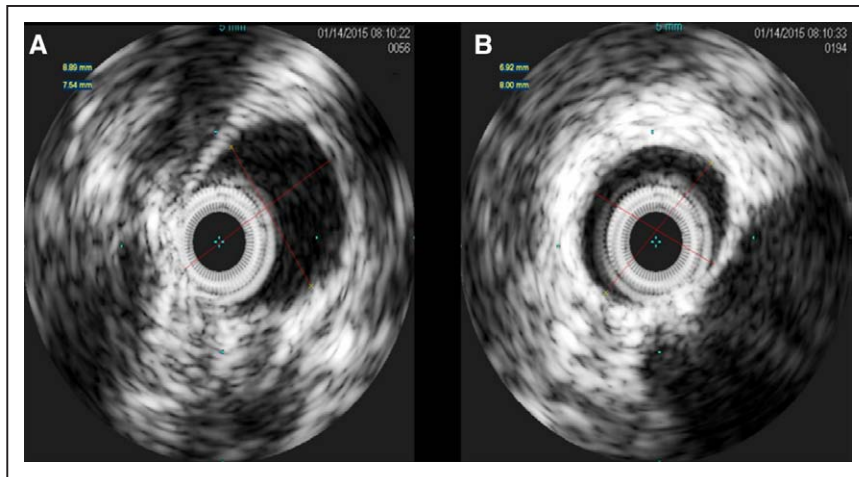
Intraoperative intravascular ultrasound images were taken of the right common femoral artery (A) and the right external iliac artery (B). The iliofemoral access site was a normal 7 to 8 mm anatomy.
